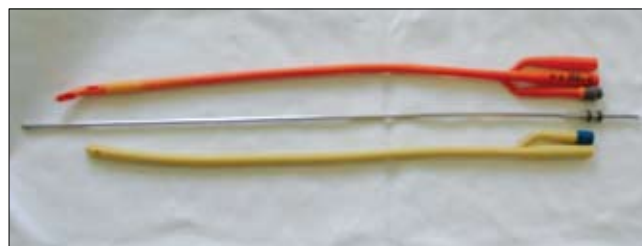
An ultrasonic probe used as a stylet for Foley and Dufour catheters.
